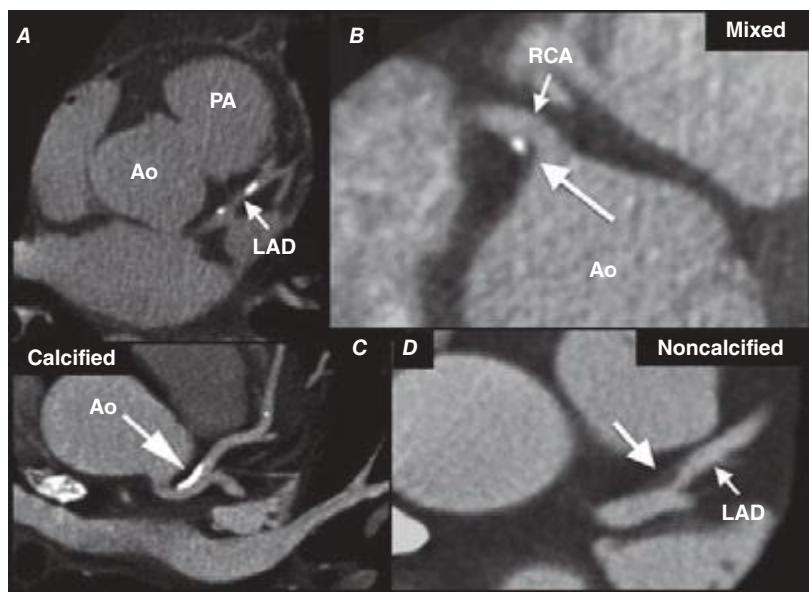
7 Examples of non-contrast- and contrast-enhanced coronary imaging with computed tomography (CT). A. Calcified coronary plaques in the distal left main and proximal left anterior descending coronary artery (LAD) in a noncontrast cardiac CT scan. Calcium deposits are dense and present as bright white structures on CT, even without contrast enhancement. B, C, and D. Different types of atherosclerotic plaques on contrast-enhanced CT scans. Importantly, noncalcified plaques are evident only on contrast-enhanced CT scans. AO, aorta; PA, pulmonary artery; RCA, right coronary artery.
